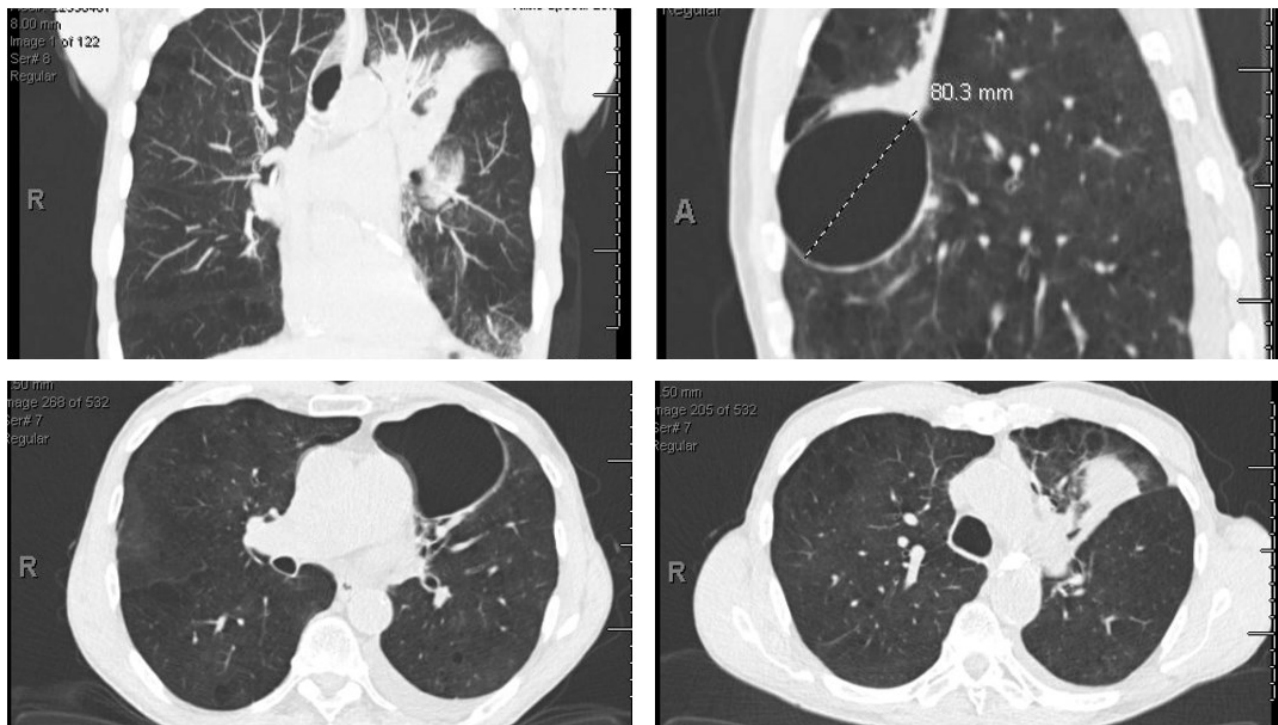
Case 2 - Computed Tomography Chest Post-BLVR
